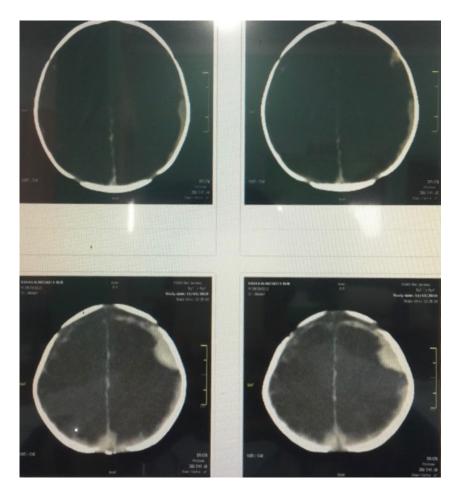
Head CT scan results, This examination shows the impression of subdural and subarachnoid hemorrhage with cerebral edema.
